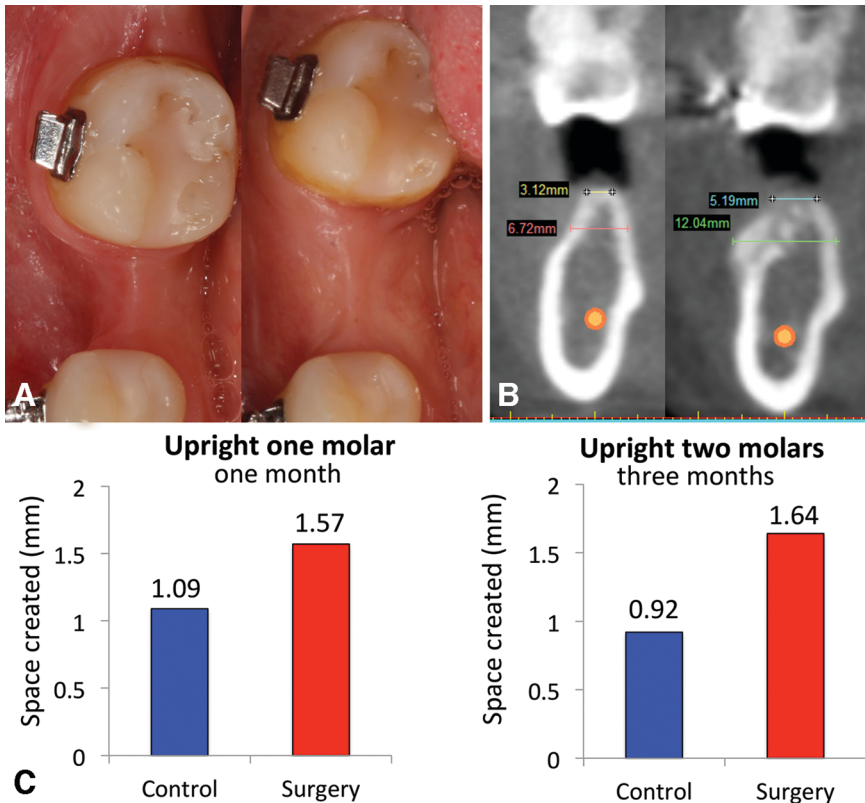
Accelerated implant site development. A: Pre- and five months post-surgery showed successful buccal-lingual horizontal ridge augmentation and mesial-distal space creation for ideal implant prosthetics. B: Pre- and post-surgery CBCT revealed ~5 mm horizontal gain. C: The speed of second molar uprighting comparing to the control side is about 1.5 to 1.8 times faster.
